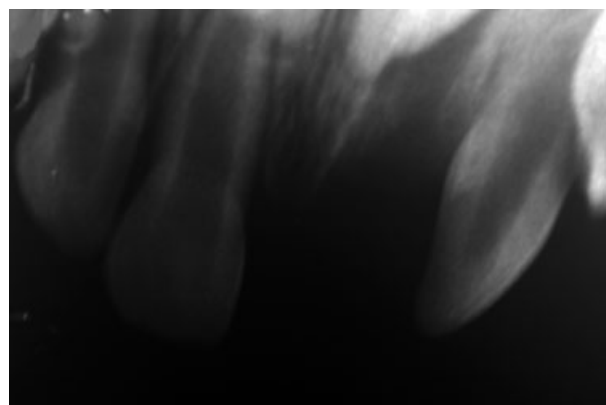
Periapical radiograph after avulsion.
